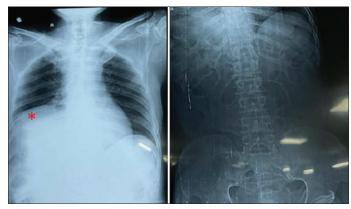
X-ray chest and abdomen: Bowel shadow under the right hemidiaphragm \*with multiple dilated bowel loops
